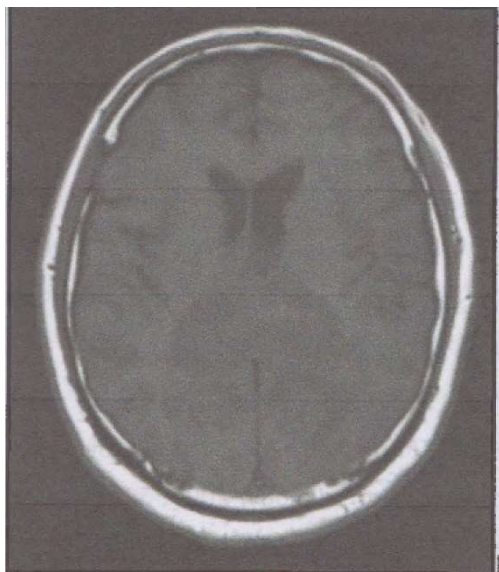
T1 W MRI brain with contrast
